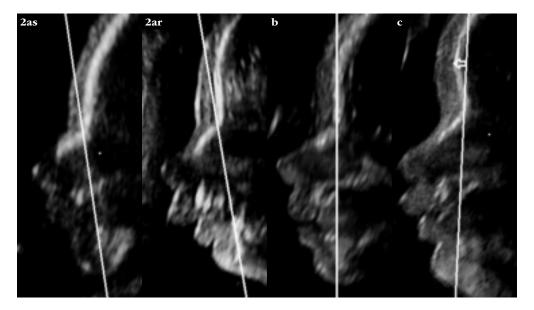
Ultrasound pictures showing examples of the 3 types FP lines. (as) and (ar), FP line is negative; (b) FP line is zero; (c) FP line is positive. Arrowindicates F distance. Fetus in picture (as) had a sloping forehead (case with trisomy 13), fetus in picture (ar) has retrognathia (case with Pierre Robin sequence), the other two fetuses are normal (case (b) at 25weeks gestational age and case (c) at 32weeks gestational age)
